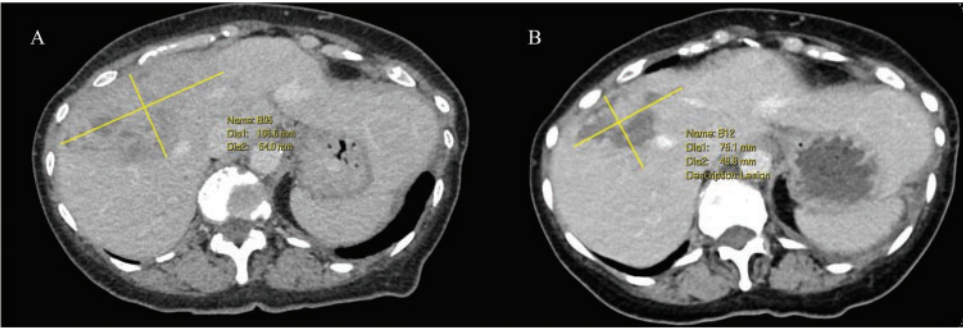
Liver computed tomography images obtained before and after fulvestrant plus capivasertib. (A) January 24, 2025; (B) February 22, 2025.
